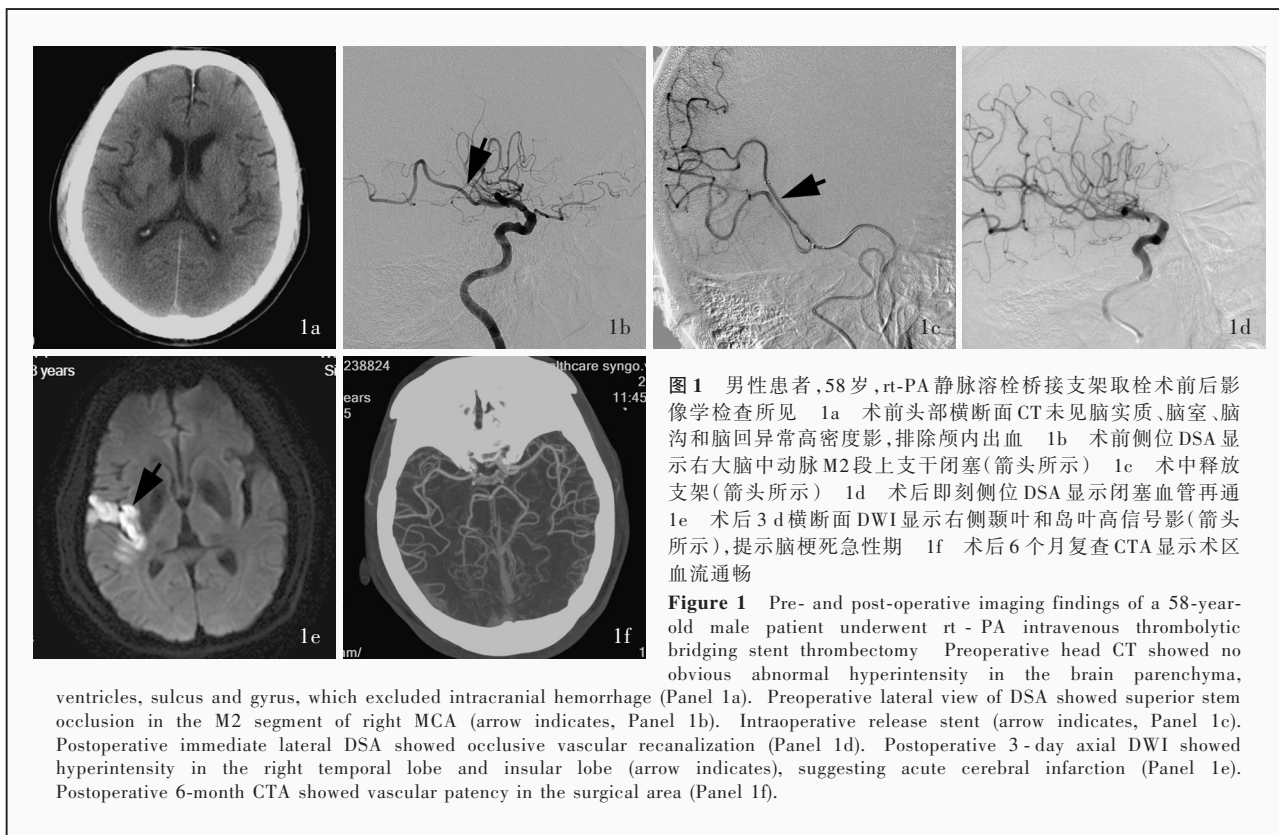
男性患者, 58 岁, rt-PA 静脉溶栓桥接支架取栓术前后影像学检查所见 1a 术前头部横断面 CT 未见脑实质、脑室、脑沟和脑回异常高密度影, 排除颅内出血 1b 术前侧位 DSA 显示右大脑中动脉 M2 段上支干闭塞(箭头所示) 1c 术中释放支架(箭头所示) 1d 术后即刻侧位 DSA 显示闭塞血管再通 1e 术后 3 d 横断面 DWI 显示右侧颞叶和岛叶高信号影(箭头所示), 提示脑梗死急性期 1f 术后 6 个月复查 CTA 显示术区血流通畅
